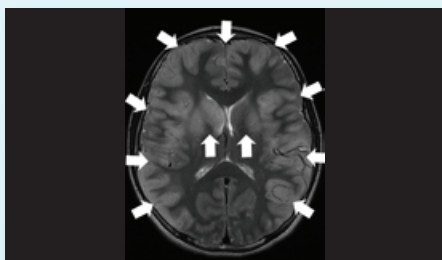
MRI brain scan from a patient with immune encephalitis following a mycoplasma throat infection. The white arrows indicate multiple areas of brain swelling, seen as lighter shades of grey.
